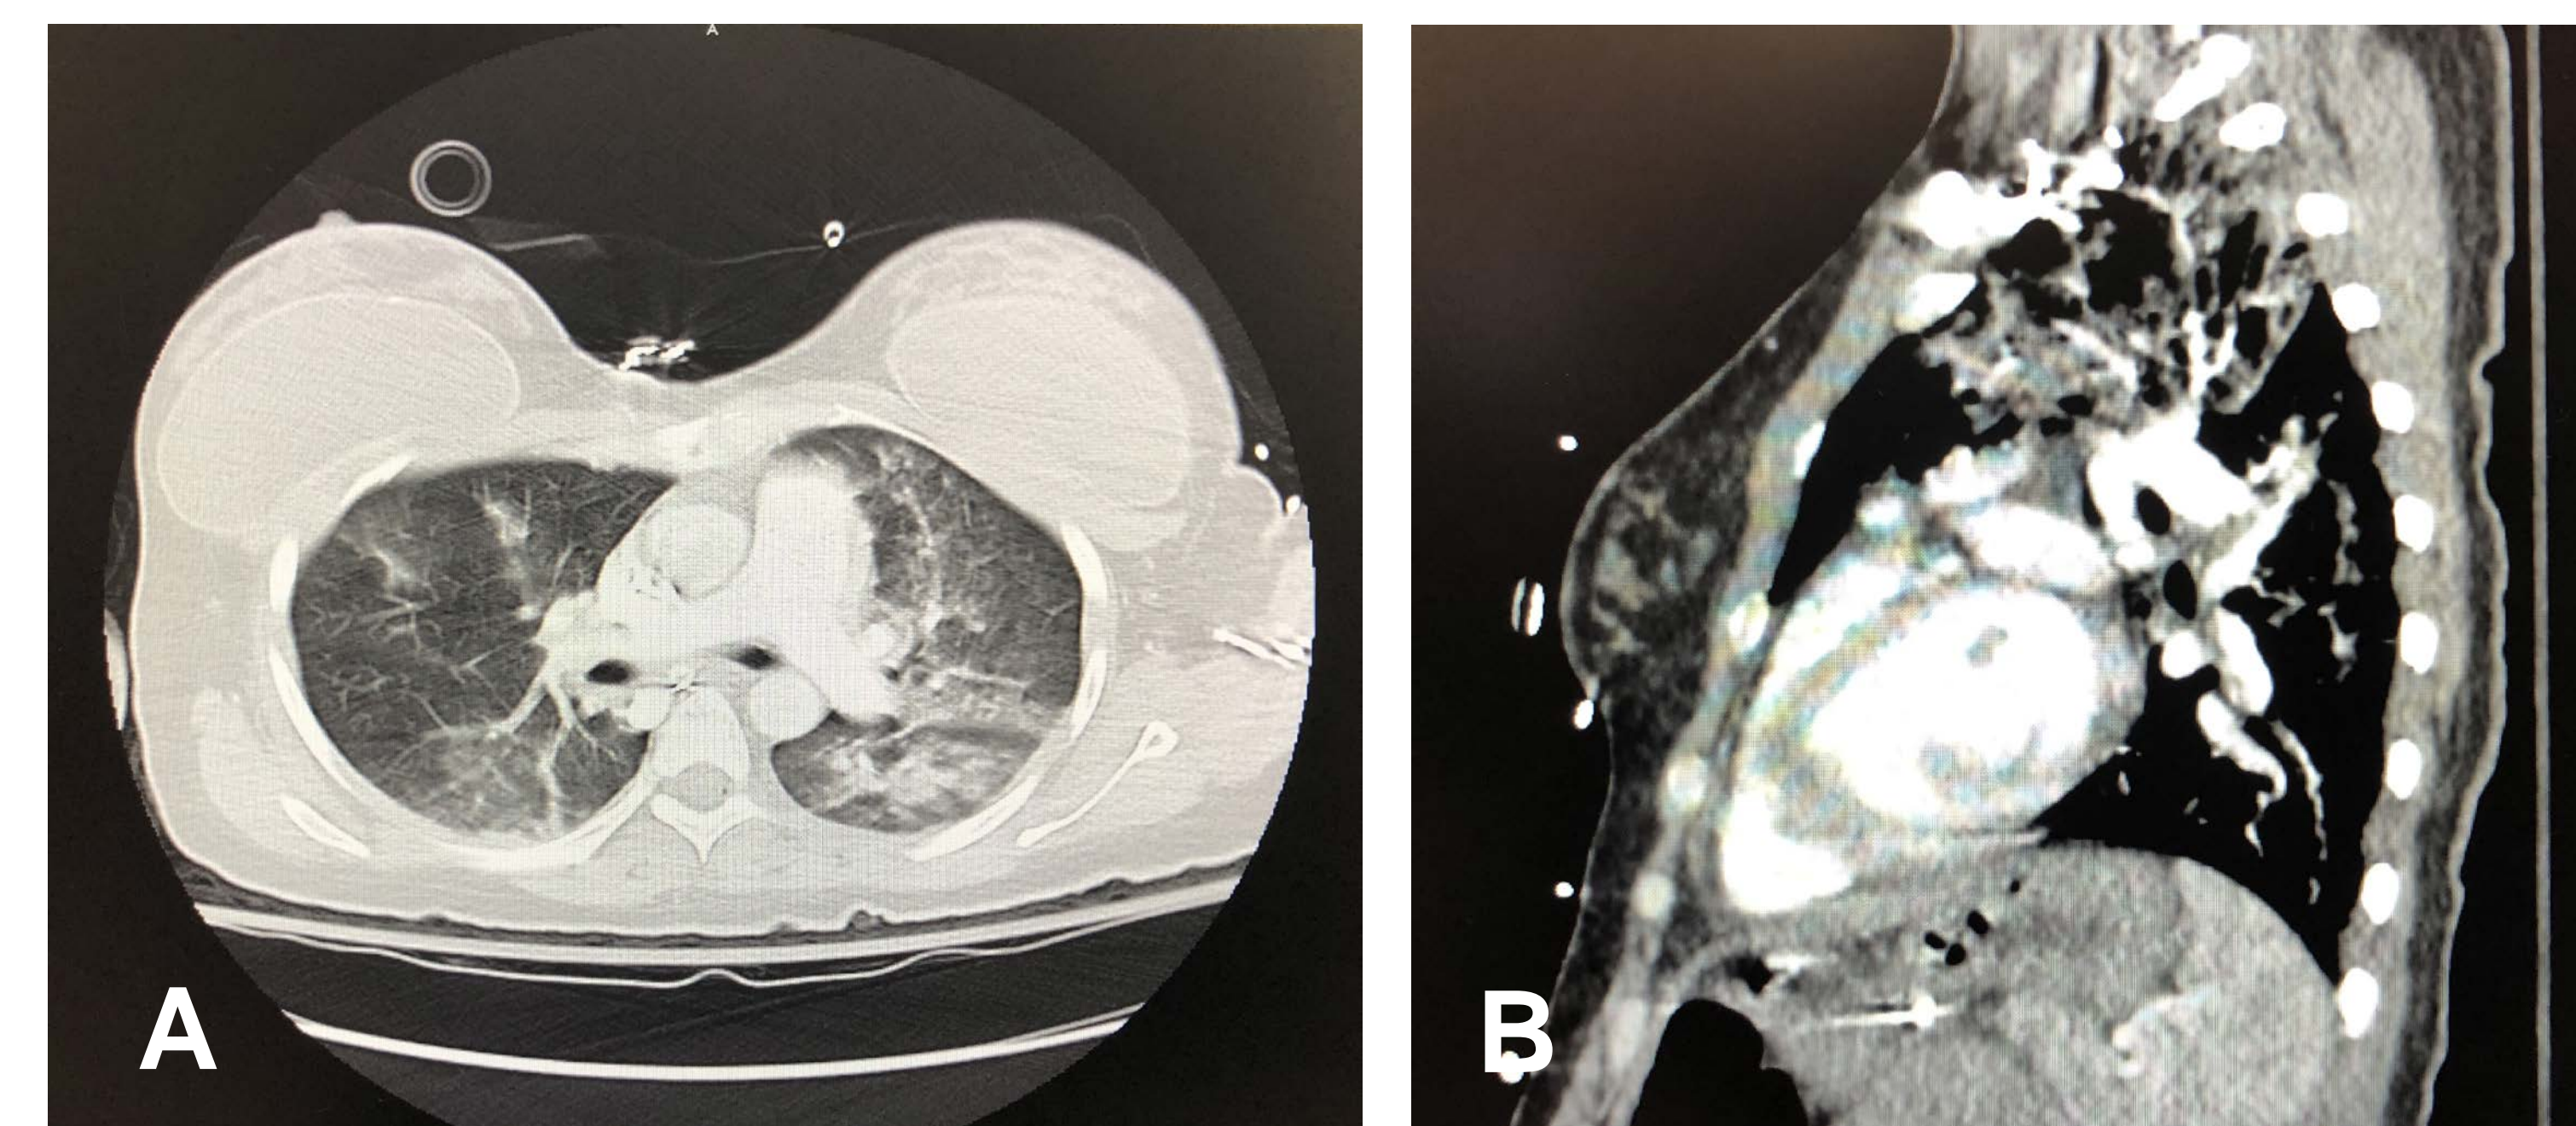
Multiple CT angiogram views of the chest showing severe airspace opacities of the left lung and moderately severe airspace opacities of the right lung suggestive of amniotic fluid embolism. No evidence of right ventricular prominence or strain pattern. A. Transverse view B. Sagittal view
